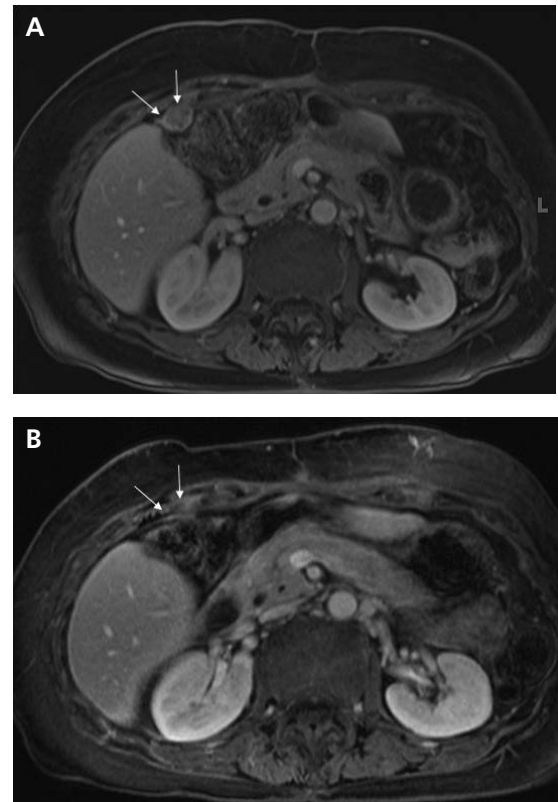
MRI imaging pretreatment and posttreatment. (A) Initial postoperative MRI images show an enhancing soft tissue peritoneal nodule (arrows) compatible with metastases. (B) Follow-up imaging after 3 months of treatment shows complete resolution of the nodule.
